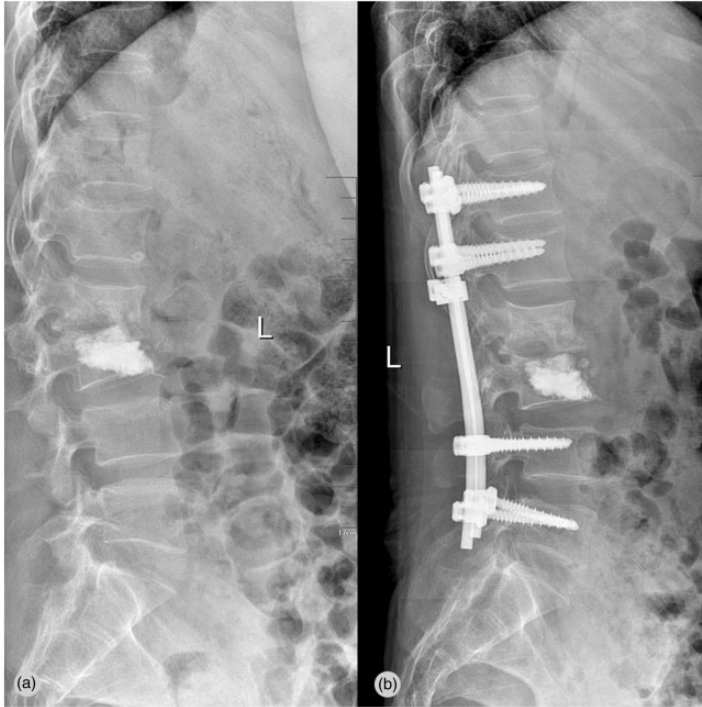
(a) Plain radiography shows severe spondylitis and collapse of disc space at the L2–L3 level, with kyphosis. (b) One month after posterior instrumentation and fusion. The metallic implant is in a good position, and there is correction of kyphosis and improvement in lumbar stability.
